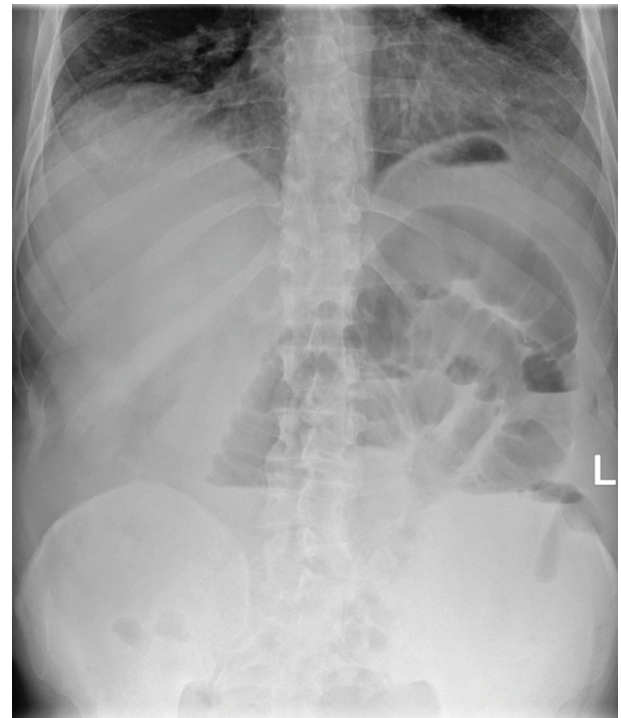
Abdominal X-ray at admission: overdistention of intestinal loops in the umbilical and left lumbar regions with associated pathological hydro-aerial levels.
